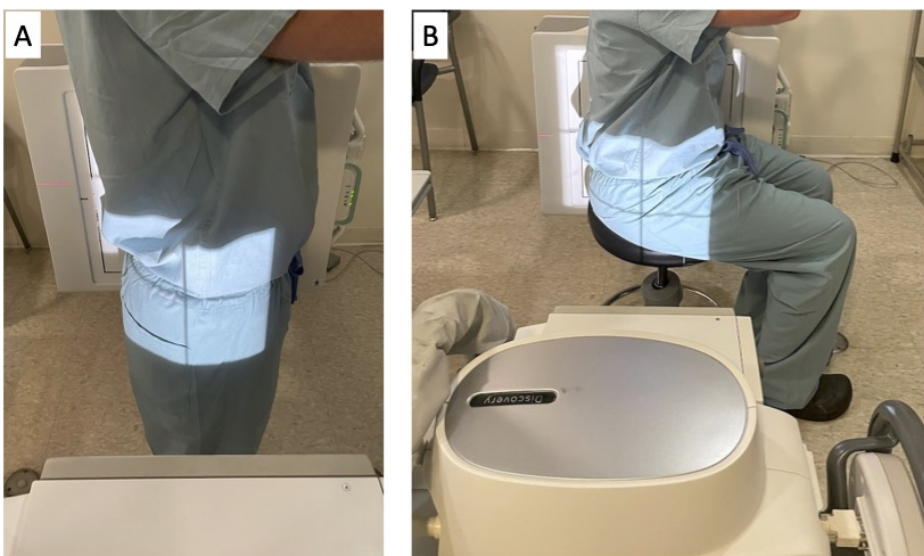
Patient positioned for standing lateral radiograph (A) and sitting lateral radiograph (B).
